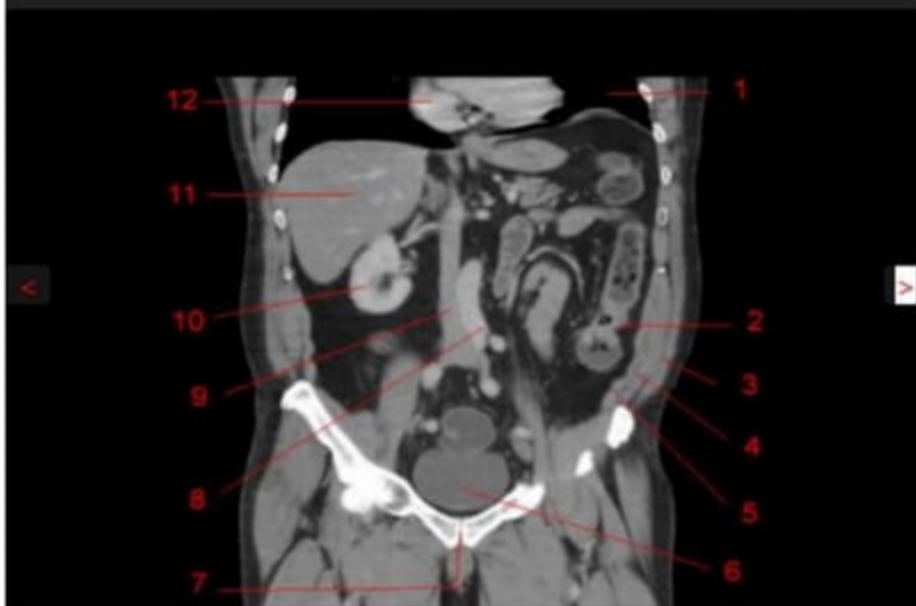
Atlas of CT Anatomy of the Abdomen. Coronal reconstruction.
